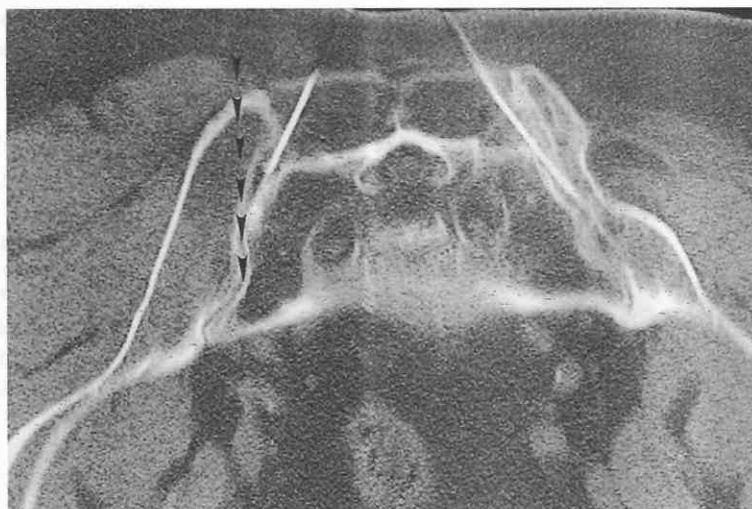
Bilateral sacroiliac joint injections with CT guidance. The left side of the sacroiliac joint was difficult to approach fluoroscopically. Arrowheads indicate the apparent approach to the left sacroiliac joint under fluoroscopy, but the iliac bone blocks access to this joint, which is somewhat curved. The right joint has a straighter trajectory and was able to be accessed with fluoroscopy. Nevertheless, CT provides the most accurate way of defining the opening to the sacroiliac joints. In this case, the true opening to the right side of joint was situated much more medially than was apparent under fluoroscopy.
